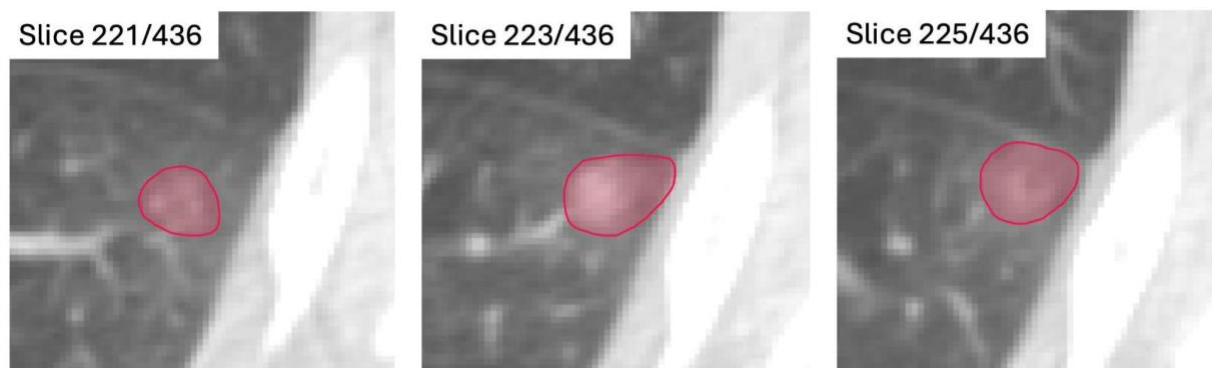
Consecutive slices of an axial view of a CT Chest opened in the RedBrick AI annotation platform, demonstrating 3-dimensional segmentation of a ground glass opacity in the superior segment of the left lower lobe.
